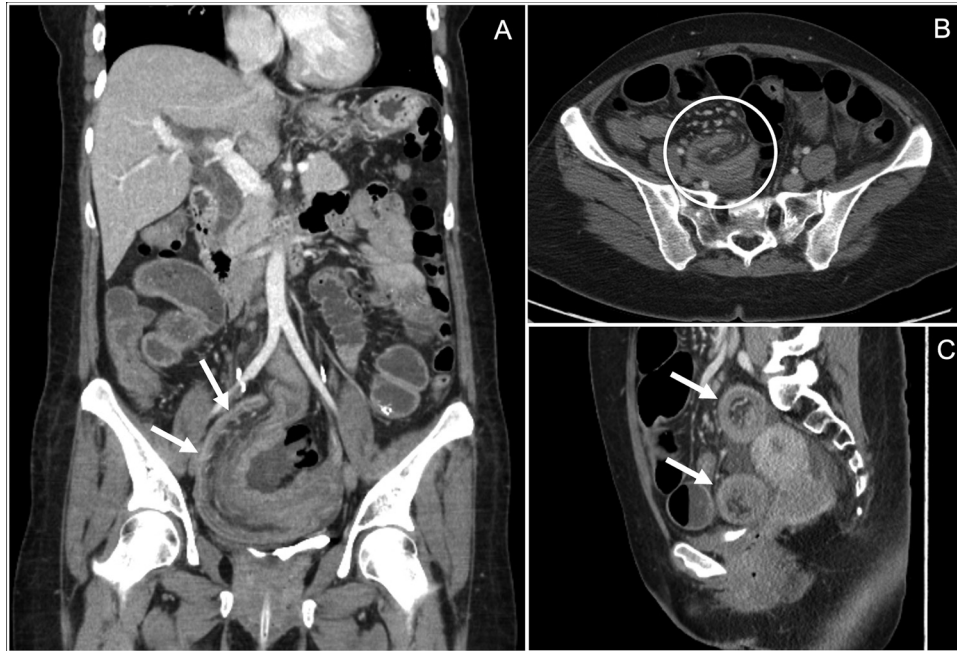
Coronal (A), axial (B), and sagittal (C) images from contrast enhanced CT of the abdomen and pelvis showing a long segment ileo-ileal intussusception in the distal small bowel. Telescoping of proximal ileum into a distal ileal segment is seen in a curvilinear or sausage shape (arrows in A). No discrete soft tissue mass or lead point is identified.
